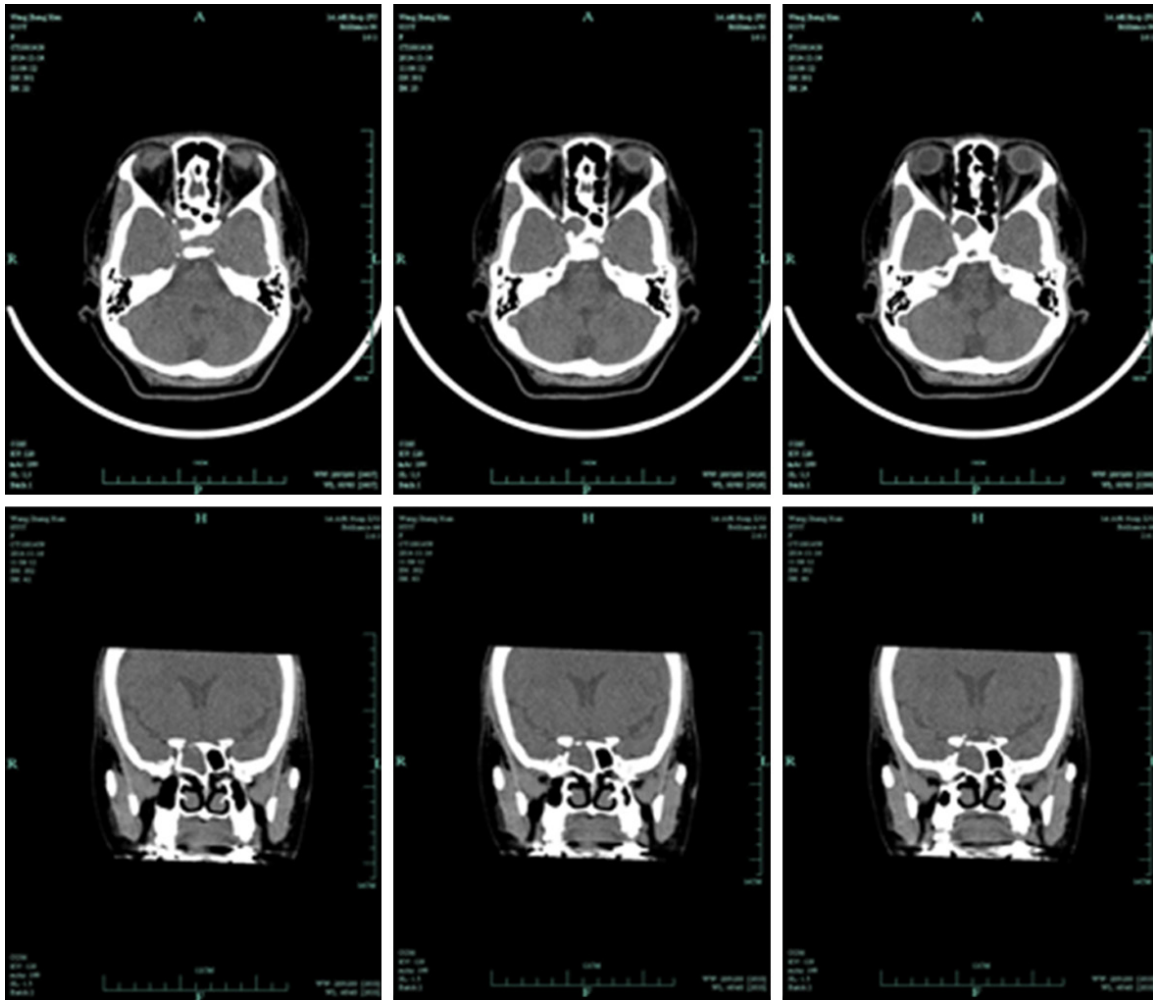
Computed tomography (CT) of the paranasal sinuses demonstrated a homogeneous soft tissue mass expanding the right sphenoid sinus and causing destruction of bone.
